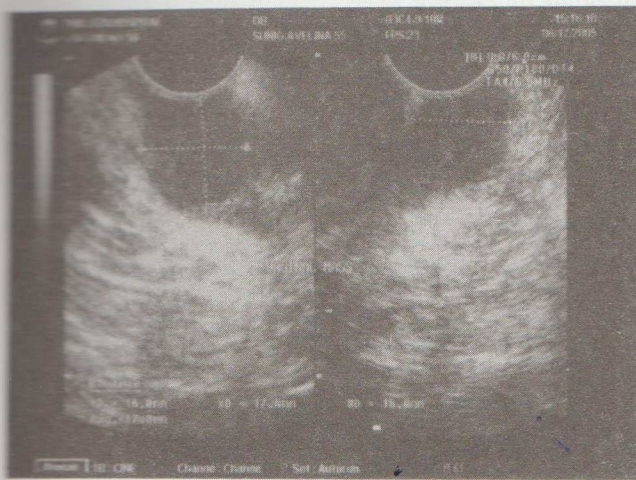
Transperineal ultrasound showing an irregular solid hypoechoic mass extending from the perineum and into the left vaginal wall measuring 1.7 cm wide and 3.8 cm thick.
